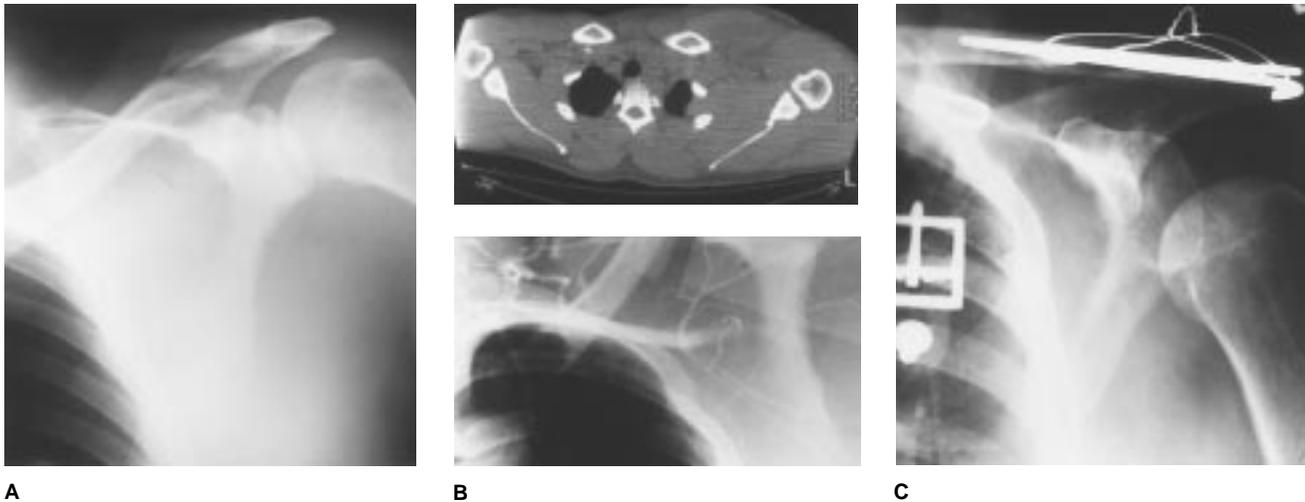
Images of a patient who sustained a left scapulothoracic dissociation. A, Preoperative AP radiograph shows significant lateral displacement of the scapula and a significantly displaced fracture of the distal clavicle. B (top), CT image shows significantly increased distance between the left scapula and the rib cage as compared with the opposite (uninjured) side. B (bottom), Arteriogram shows disruption of the subclavian artery. C, Postoperative AP radiograph shows reduction and stabilization of the distal clavicle (and secondarily the scapulothoracic articulation) obtained with use of a tension-band technique.
